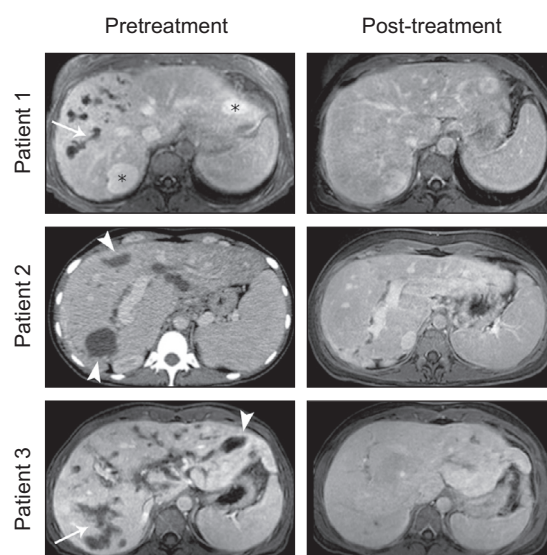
Radiologic improvement in biliary disease after treatment with intravenous anti-vascular endothelial growth factor in patients with hereditary hemorrhagic telangiectasia. Contrast-enhanced T1-weighted MRI images and contrast-enhanced CT image (Patient 2, left column) obtained during the portal venous phase, before (left column) and after treatment (right column). Pre-treatment imaging demonstrates dilatation of the intrahepatic ducts (arrows) and multiple well-defined hypointense/hypodense lesions in keeping with intrahepatic bilomas (arrowheads). Peripheral rim enhancement is observed in Patient 3 (left column), suggestive of superimposed infection. Following treatment, there is resolution of the bilomas and near-complete resolution of the intrahepatic biliary dilatation (right column). Incidental note made of two hepatic hemangiomas (*) in patient 1.
